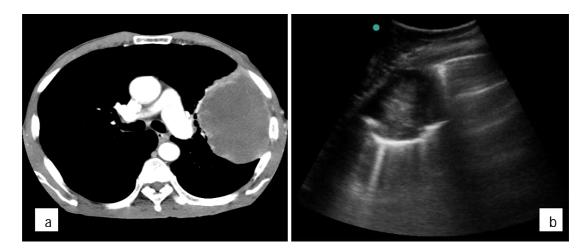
Chest CT (a) and US (b) of peripheral lesions abutting the chest wall amenable to TTNA.
